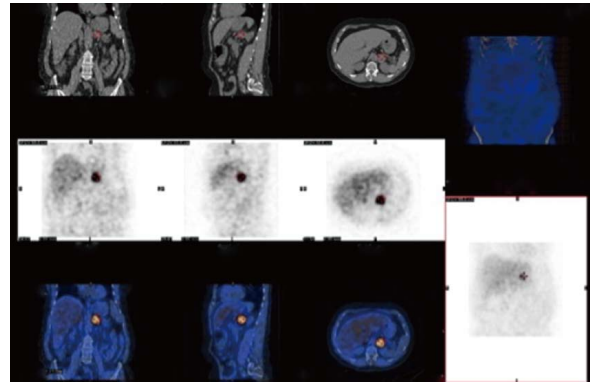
I-123-metaiodobenzylguanidine-SPECT images demonstrated focal increased tracer activity in the left adrenal nodule compatible with metaiodobenzylguanidine avid tumor.
